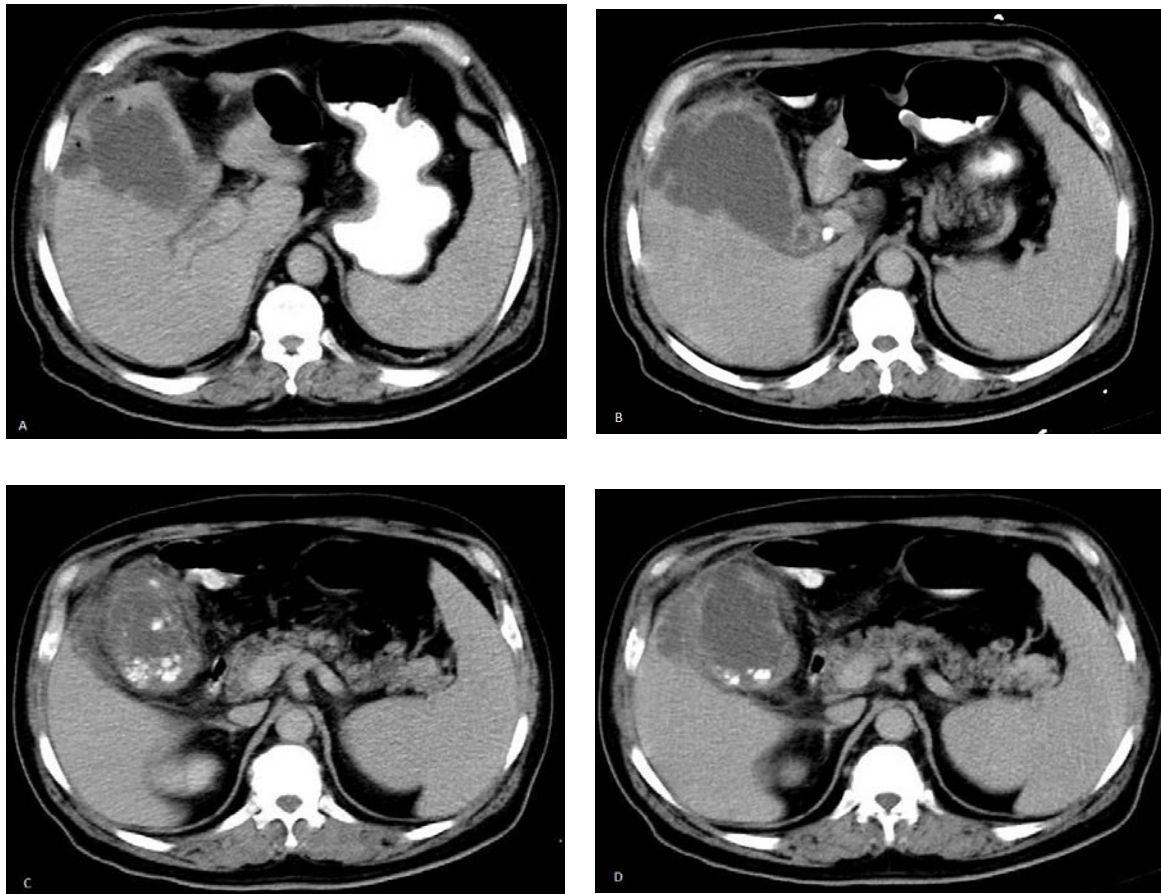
Axial oral and intravenous contrast-enhanced abdominal computed tomography (CT) scan of the patient
